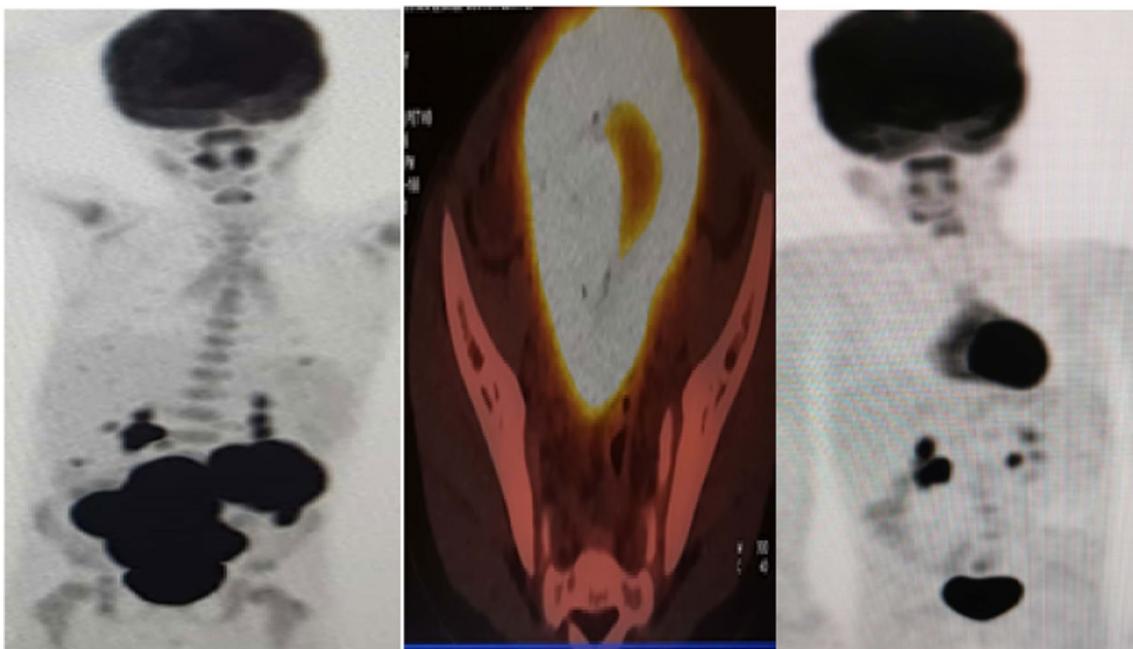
PET-CT study for a 5-year-old male child presented with an abdominal mass. To the left: Initial study shows metabolically active FDG-avid abdomino-pelvic bowel mass. The mid image: Fused PET-CT image shows FDG-avid abdomino-pelvic bowel mass with marked mucosal thickening. To the right: Interim PET-CT study shows complete disappearance of all lesions. Both visual and semiquantitative interpretation methods were negative, and the patient was free till the last follow-up
